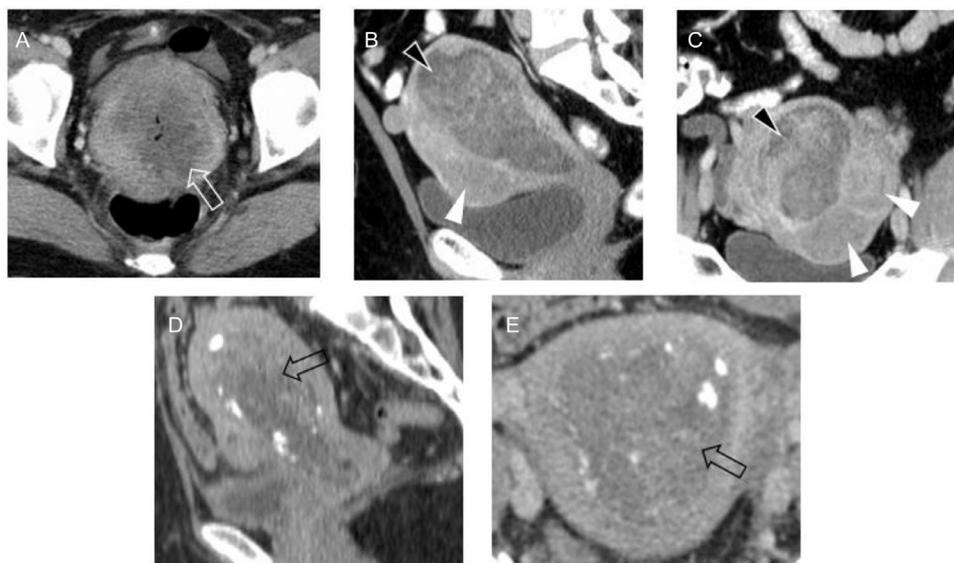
Neoplasm of the cervix and endometrium can have a wide range of appearances. (A) axial CT image shows a heterogeneous cervical squamous cell carcinoma with central gas and necrosis (open arrow). (B) and (C) sagittal and axial CT images show a heterogeneous endometrial mass biopsy proven to be endometrial adenocarcinoma (black arrowhead). (D) and (E) coronal and axial CT images show an enlarging heterogeneous endometrial mass mistaken for a fibroid with calcifications, but show to be a mixed malignant müllerian tumor, aka carcinosarcoma, with osteosarcoma elements (black open arrow).
